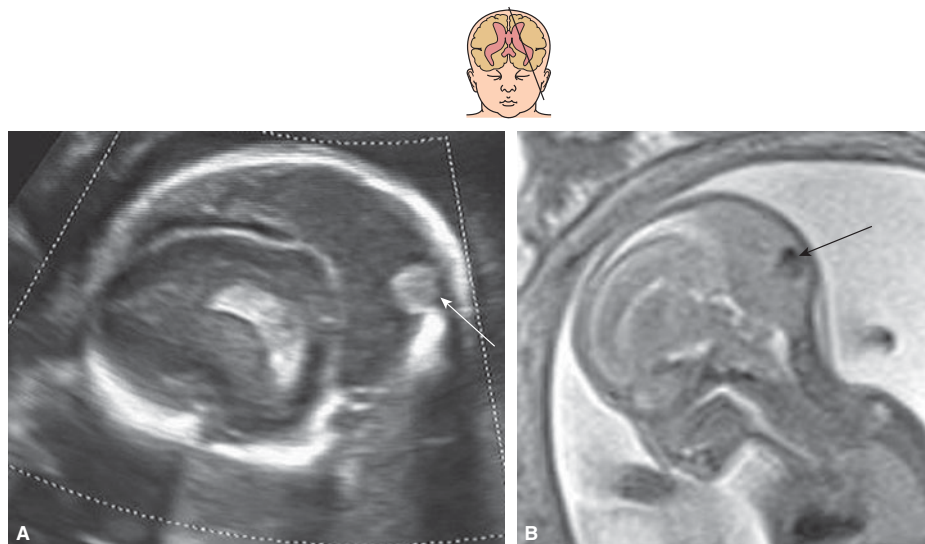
Juxtaposition of the same sagittal planes of the sinus thrombosis seen on Figure 10-14. (The arrows point to the thrombus). (A) Ultrasound. (B) MRI.
